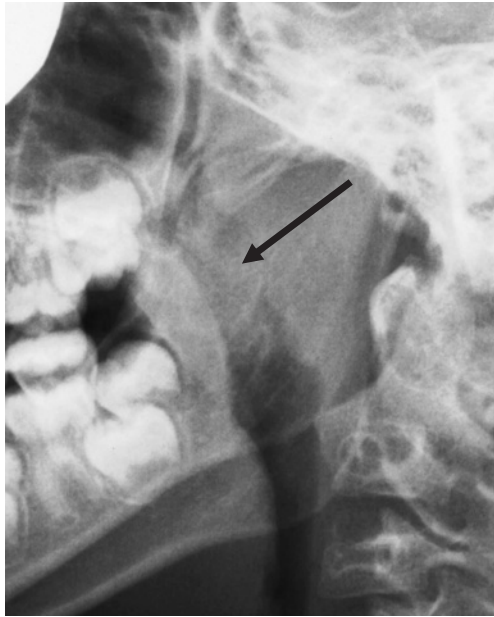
A lateral neck radiograph shows a markedly enlarged mass obstructing the retropharyngeal airway.
